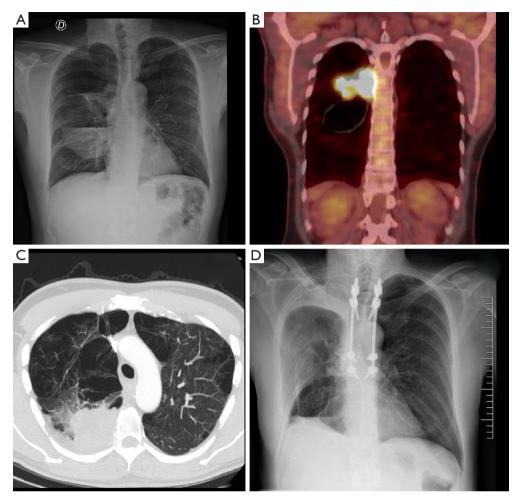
Pre- and post-operative imaging tests. (A) X-ray at diagnosis. (B) Pre-surgical PET-CT. (C) Pre-surgical CT. (D) X-ray at discharge. PET-CT, positron emission tomography-computed tomography; CT, computed tomography.
